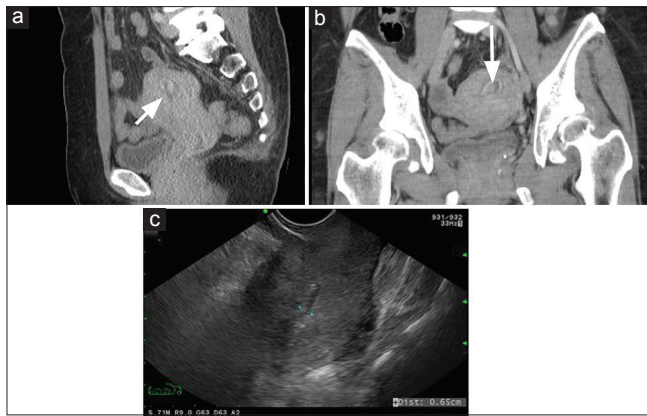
Image study of uterus. Abdominal to pelvis computed tomography on May 12, 2017 showed a 1.9 cm nodule with enhanced wall in uterine cavity. (a) Sagittal section; (b) coronal section. (c) Ultrasound of uterine endometrium
